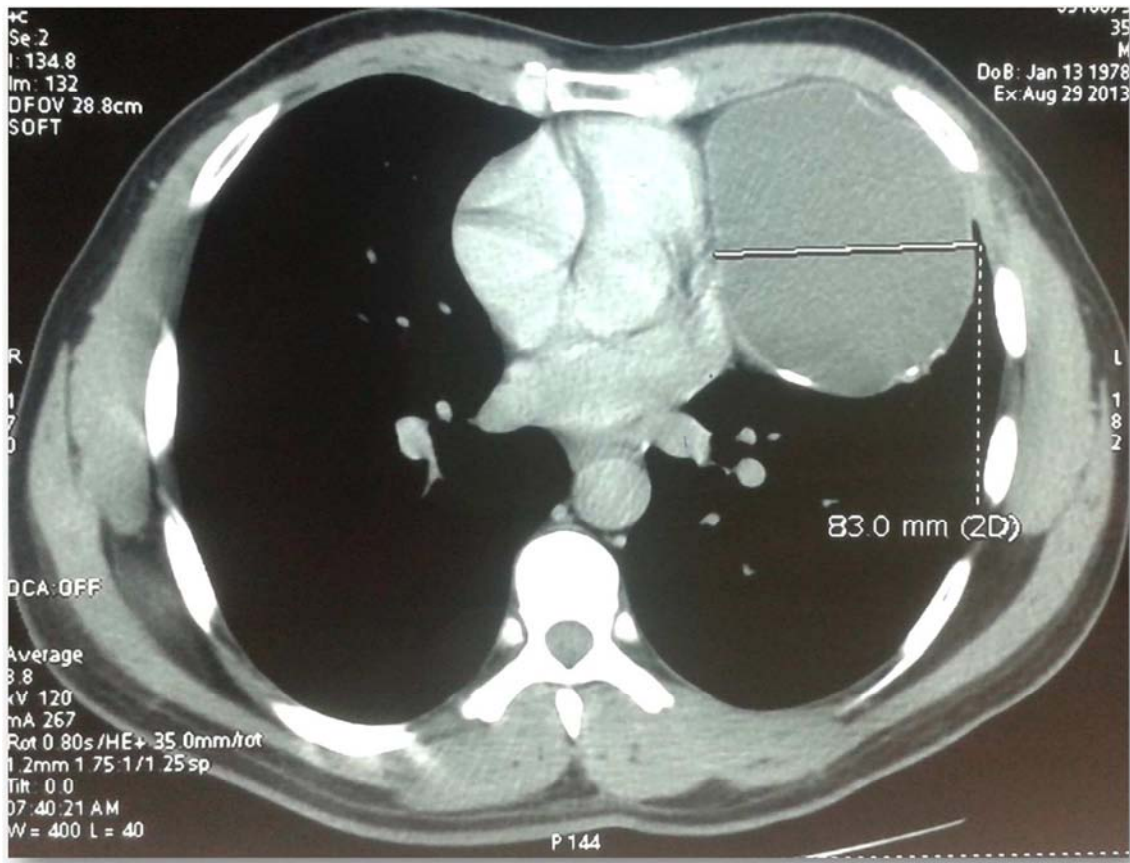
CT scan showing a cystic mass of the left cardiophrenic angle.
